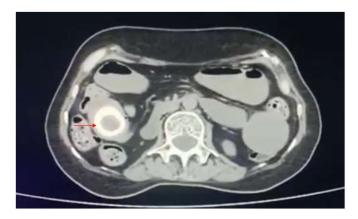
Note the CT of the abdomen and pelvis, axial section, Showing an impacted stone in the ileocecal trasition (red arrow)
